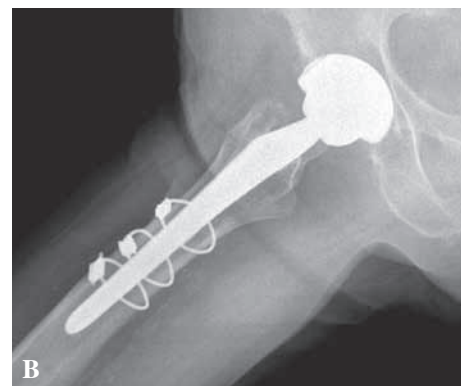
One year post operative AP and lateral radiographs show complete bone healing.
